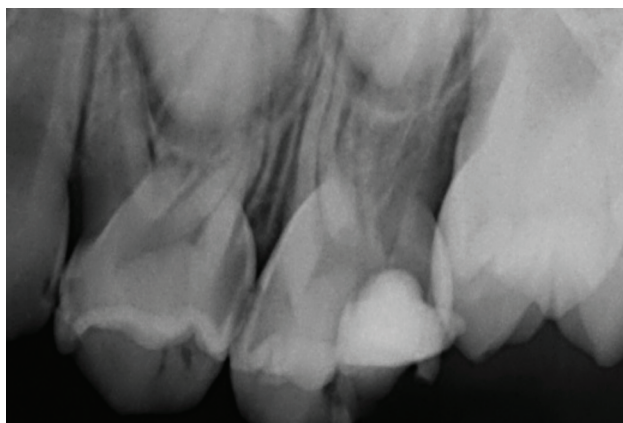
Periapical radiograph of the upper right deciduous dentition highlighting interproximal caries in which the Atraumatic Restorative Technique (ART) has been used.
